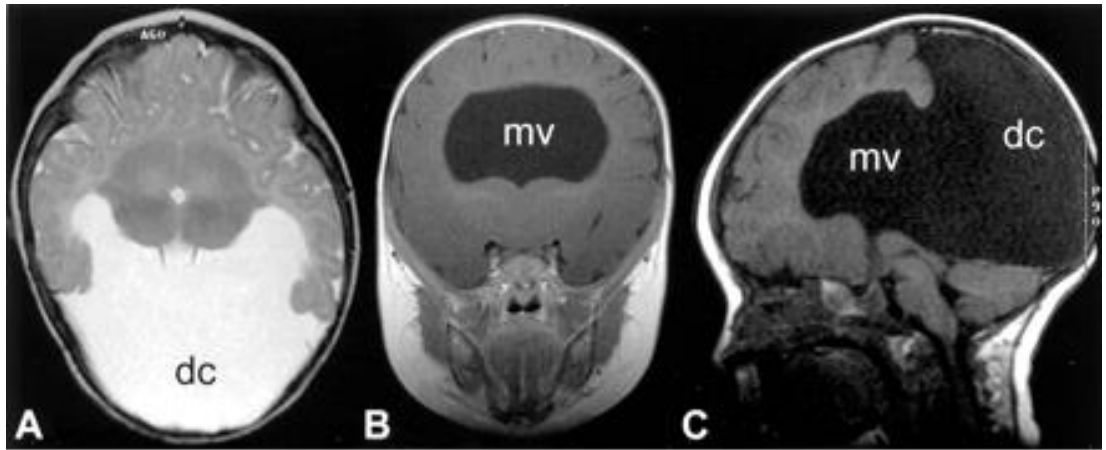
MRI scans of holoprosencephaly patients. Taken and adapted from Plawner *et al.* (Plawner *et al.*, 2002). (A, B and C) MRI of a patient with alobar holoprosencephaly (HPE). (A) A transverse image with incomplete separation of the two hemispheres, striatum, and thalami, and a large dorsal cyst (dc). (B) Coronal image showing continuity of grey matter over the two hemispheres without an interhemispheric fissure. The ventricular system is composed of a single midline ventricle, monoventricle (mv). (C) Sagittal image with absence of the corpus callosum and a monoventricle that communicates freely with the dorsal cyst. (D, E and F) MRI of two patients with semilobar HPE. (D-E) Transverse and coronal images respectively, from the same patient. Posterior portions of the hemispheres are well separated, however the anterior cerebral hemispheres are not cleaved and there is presence of a dorsal cyst (dc). Posterior horns of the lateral ventricles are well formed but frontal horns are poorly developed. (E) Posteriorly there is a monoventricle demonstrated on a coronal image. (F) Sagittal image showing that the posterior portion of the corpus callosum is formed (arrowhead), however the anterior portion is not developed; highly characteristic of semilobar or lobar HPE. (G, H and I) MRI of a patient with lobar HPE. (G) Transverse image of the cerebral hemispheres showing fair separation both anteriorly and posteriorly. There is some development of the frontal horns (arrowheads). (H) Coronal image showing failure of complete cleavage of the frontal lobe. (I) Sagittal image showing that the posterior portion of the corpus callosum (arrowhead) is formed, however the anterior portion is not developed. (J-K) MRI scans from a normal control individual for comparison to all other images A - I. (J) A sagittal image showing a normal fully formed corpus callosum (arrowhead). (K) A coronal image showing normal separation of the two hemispheres of the brain.
